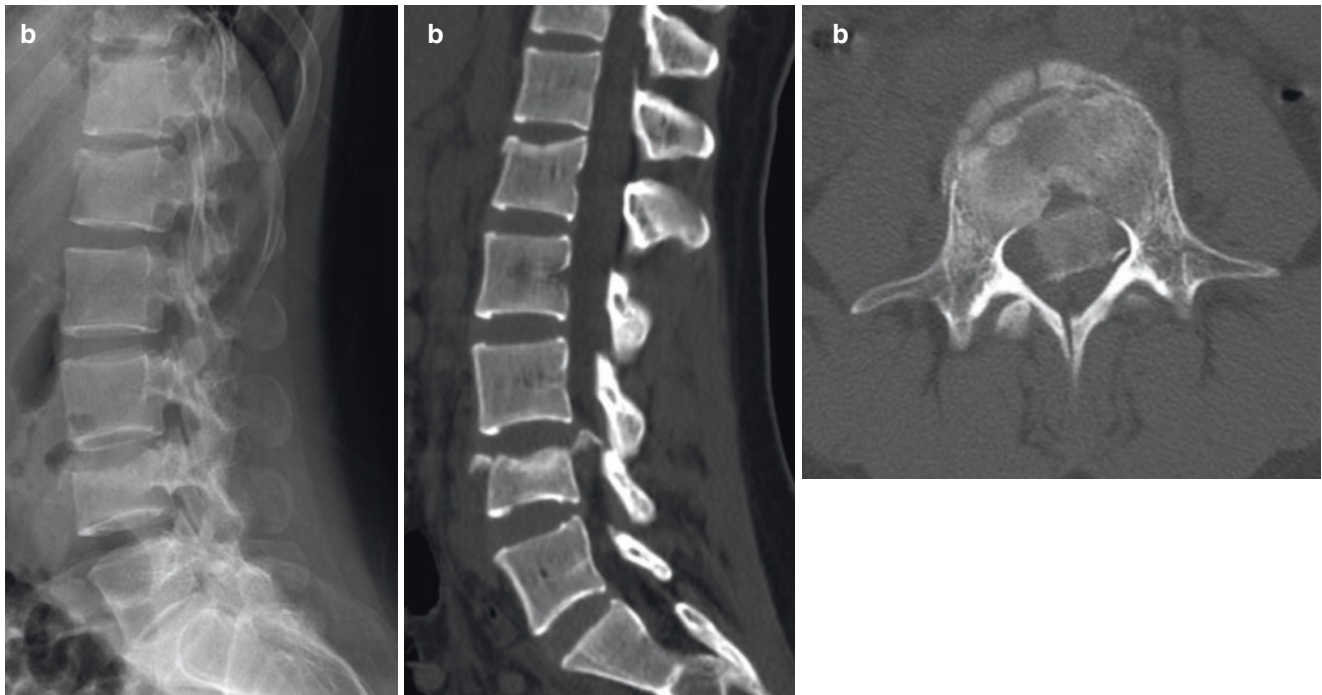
A 28-year-old male with spinal injury after falling downstairs while intoxicated. The lateral radiograph (a) shows a mild superior endplate compression fracture of L1 with anterior cortical disruption and minimal height loss. Note the sclerosis below the superior endplate. The L4 vertebral body shows a burst fracture with height loss extending to the posterior vertebral margin. Sagittal CT (b) shows
